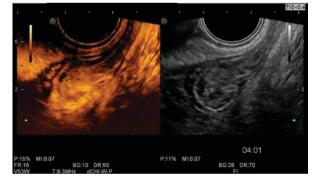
Echogram of rectal adenoma with contrast-enhanced ultrasound in IMAX mode, hyper contractive homogeneous enhancement of the tumor marked
